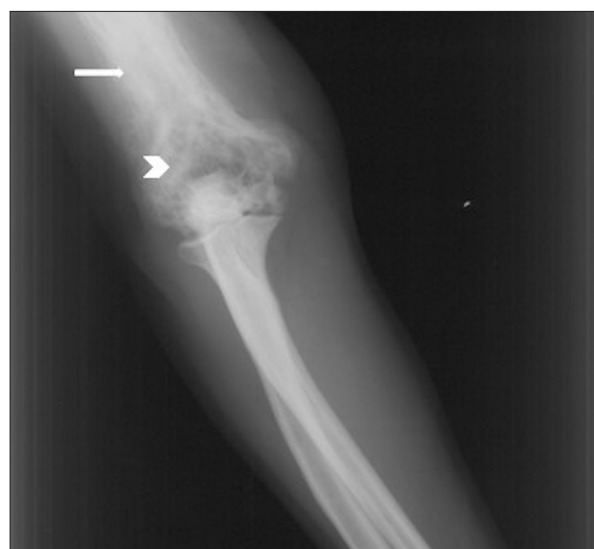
X-radiograph of the elbow joint in a 74-year-old man with Paget disease and rheumatoid arthritis. X-radiograph of the elbow joint shows cortical thickening of the distal diaphysis (arrow). Marked lytic bone lesions of the left elbow and distal humerus are present (arrowhead).
